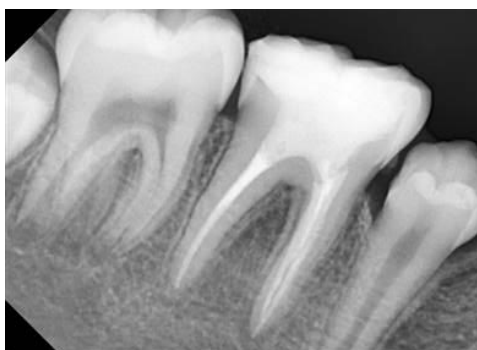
3 months follow-up visit. Healing was observed in the furcation and the periapical areas of tooth # 46.
